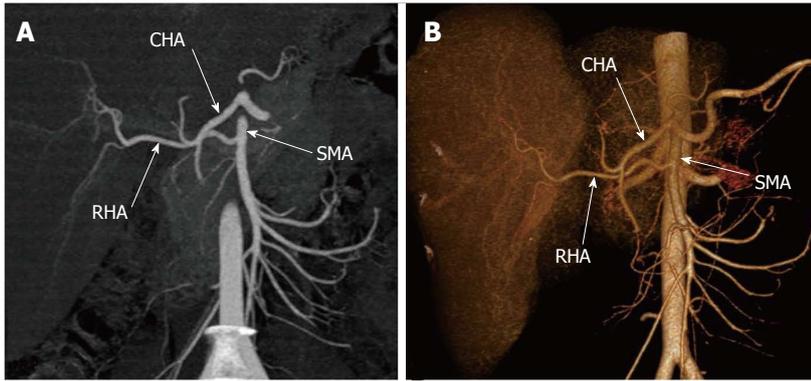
Maximum intensity projection (A) and volume rendered (B) images generated from a computed tomography angiogram shows Michel type III variant with a replaced right hepatic artery arising from the superior mesenteric artery. RHA: Right hepatic artery; SMA: Superior mesenteric artery; CHA: Common hepatic artery.
